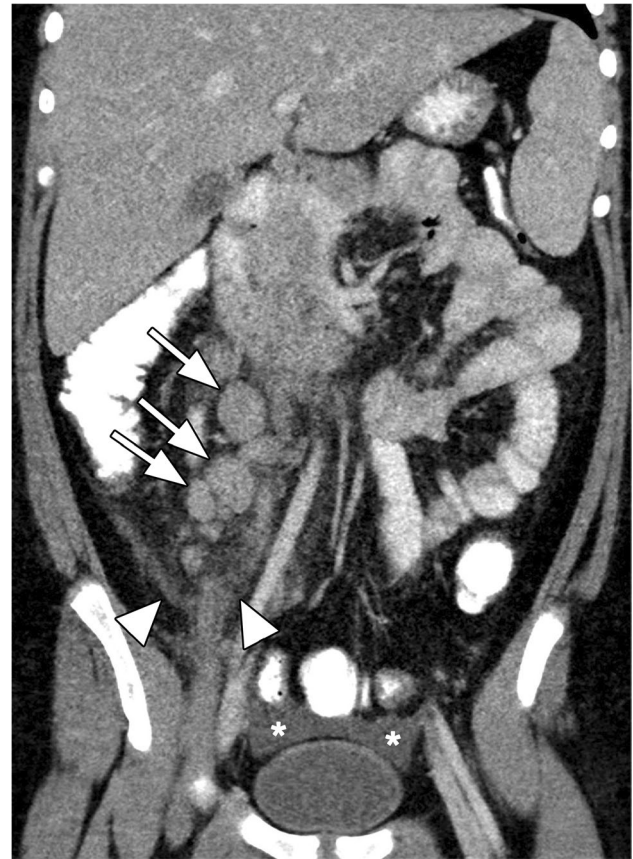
Abdominal CT findings in a 13-year-old boy with multisystem inflammatory syndrome in children (MIS-C) who presented with fever, abdominal pain and tachycardia. Coronal contrast-enhanced abdominal CT image demonstrates multiple enlarged right lower quadrant lymph nodes (arrows) and stranding of the surrounding mesenteric fat (arrowheads). A small amount of pelvic ascites is also present (*)
